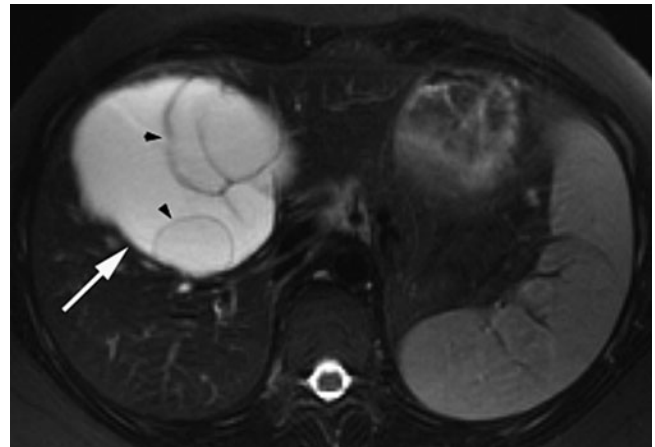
Biliary cystadenoma. T2-weighted MR image shows very-high-signal-intensity mass (*arrow*) mostly homogeneous in appearance with exception of a few, thin internal septations (*arrowheads*).
